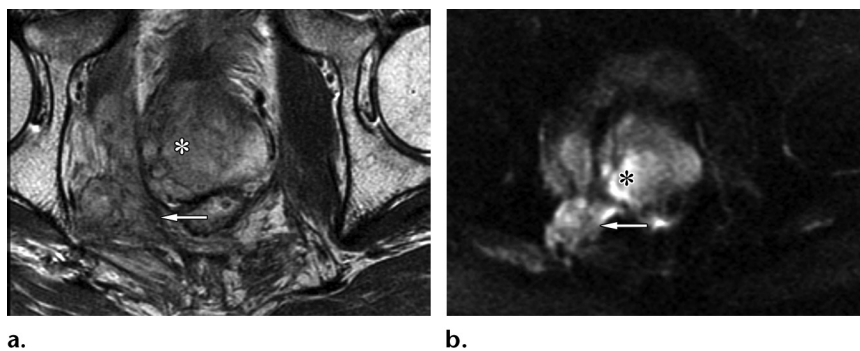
Rectal cancer in a 52-year-old man. An MR imaging examination was ordered for treatment planning. (a) Axial T2-weighted MR image shows a large multilocular lesion (*) with intermediate signal intensity that involves nearly the entire prostate, as well as an infiltrative mass (arrow) along the right pelvic sidewall. (b) Axial diffusion-weighted MR image shows restricted diffusion within the tumor (*) and the infiltrative mass (arrow). Gadolinium-based contrast material was not administered because of the patient's low glomerular filtration rate.
